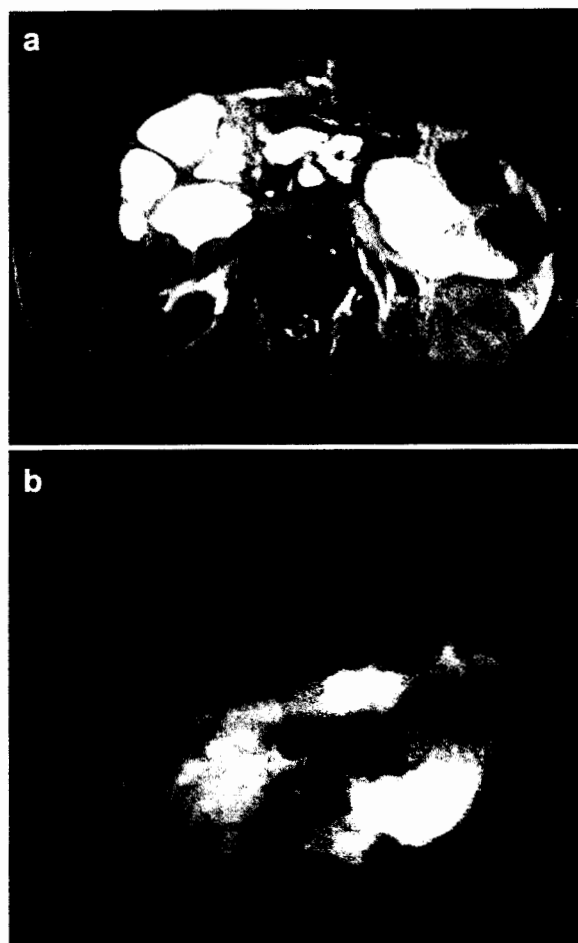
A 32-year-old man with pancreatic laceration following motor vehicle collision. Axial fast spin echo T2-weighted MR image (a) shows peripancreatic and intrapancreatic fluid collections occupying the space between the gland fragments. MR cholangiopancreatogram (b) shows peripancreatic fluid collection and ductal system integrity. Note the origin of the V biliary branch from the common bile duct
